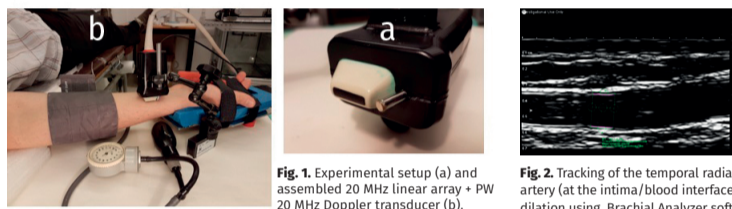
Experimental setup (a) and assembled 20 MHz linear array + PW 20 MHz Doppler transducer (b).
